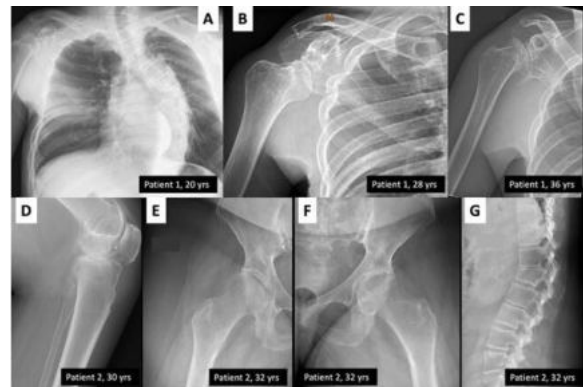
Development of skeletal abnormalities in patients from Family 2 as they become adults. A, B, and C radiographs of Patient 1 at 20, 28, and 36 years old, demonstrating progressive deformity, osteolysis, and severe scoliosis. D, E, F, and G In addition to a vertebral compression fracture in the spine, radiographs of Patient 2 taken at ages 30 and 32 reveal widespread osteopenia, osteolysis, and osteoarthritis in the knee and hip joints. [21].
